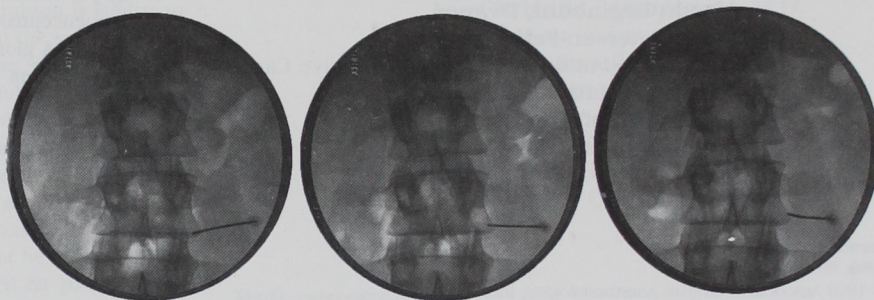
A lumbar sympathectomy is performed at L2 by "walking" the needle laterally using the bowing technique. A slight bow in the needle can be seen in the radiograph on the far right.
